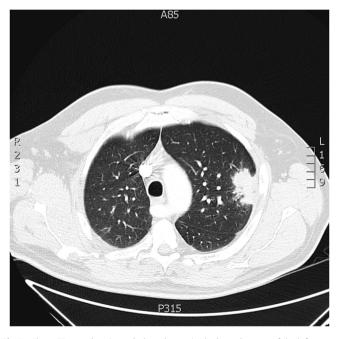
Chest CT scan showing subpleural mass in the lateral aspect of the left upper lung lobe and a smaller spiculated and eccentrically cavitary 1.4 cm nodule in the posterior and subpleural aspect of the left lower lobe.
